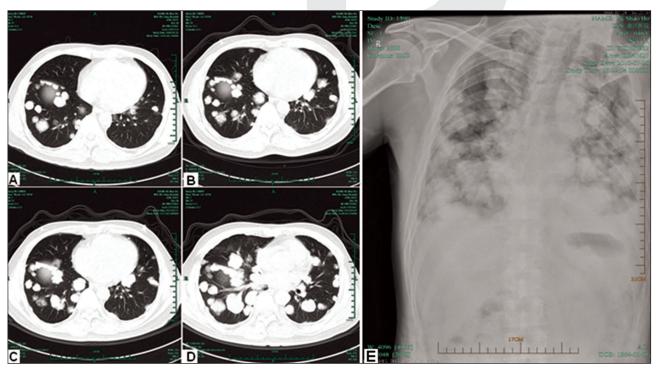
The chest CT scan and radiograph of the patient with advanced ACC. A. Chest CT scan performed in May 2009, prior to gefitinib administration, showing multiple pulmonary metastases. B. Chest CT scan in December 2009, at 7 months after the start of gefitinib administration. C. Chest CT scan in February 2010, at 10 months after the start of gefitinib administration. D. Chest CT scan in April 2010, at 2 months after the start of sunitinib administration. E. Chest radiograph in July 2010, at 5 months after the start of sunitinib administration, showing progression of the pulmonary lesions
